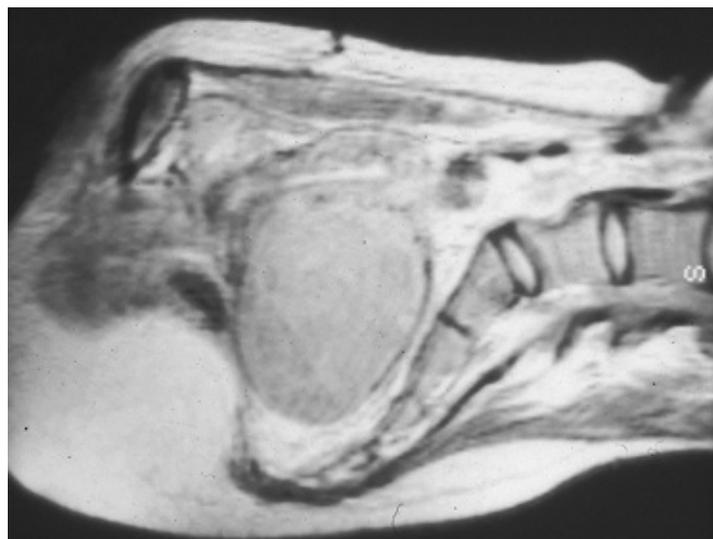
MRI of leiomyomata. This MRI demonstrates a large leiomyomata arising from the posterior aspect of the uterus and filling the entire pelvis. It directly contacts the promontory of the sacrum.
